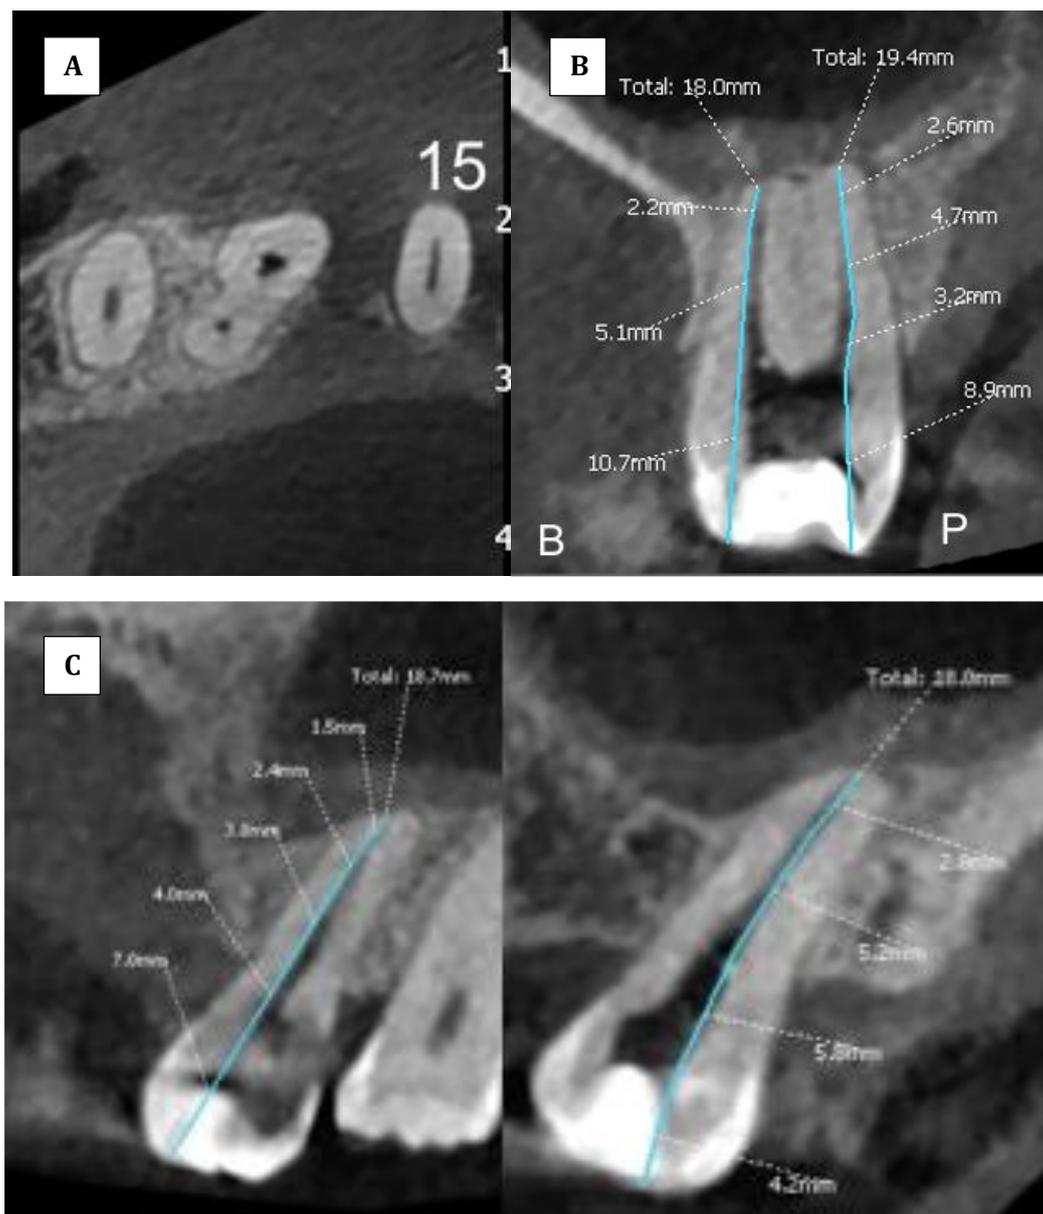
CBCT images showing two distinct buccal and palatal roots and root canals: (A) axial section, (B) coronal section, (C) sagittal section.
